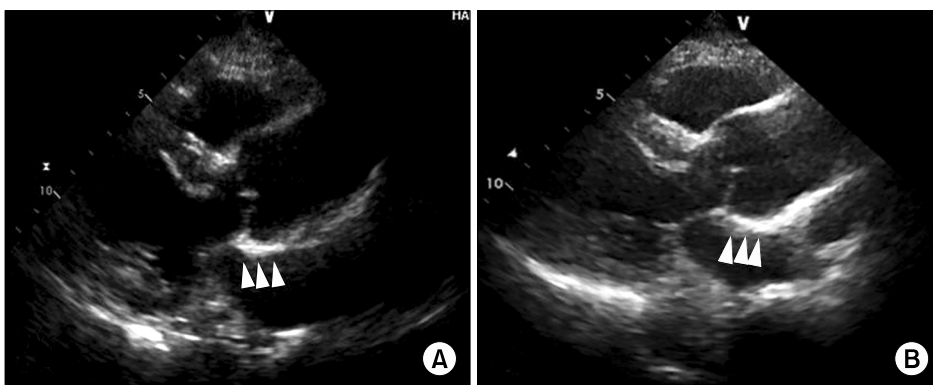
Comparison of transthoracic echocardiographic images on the parasternal long-axis view between pre-discharge (A) and 12 months postoperatively in patient 5 (B). Echocardiographic images show that the root geometry was preserved well without dilatation; a hyper-echogenic structure (arrowheads) corresponds to the non-coronary sinus with a rectangular patch for reinforcement and an annular fixation.
